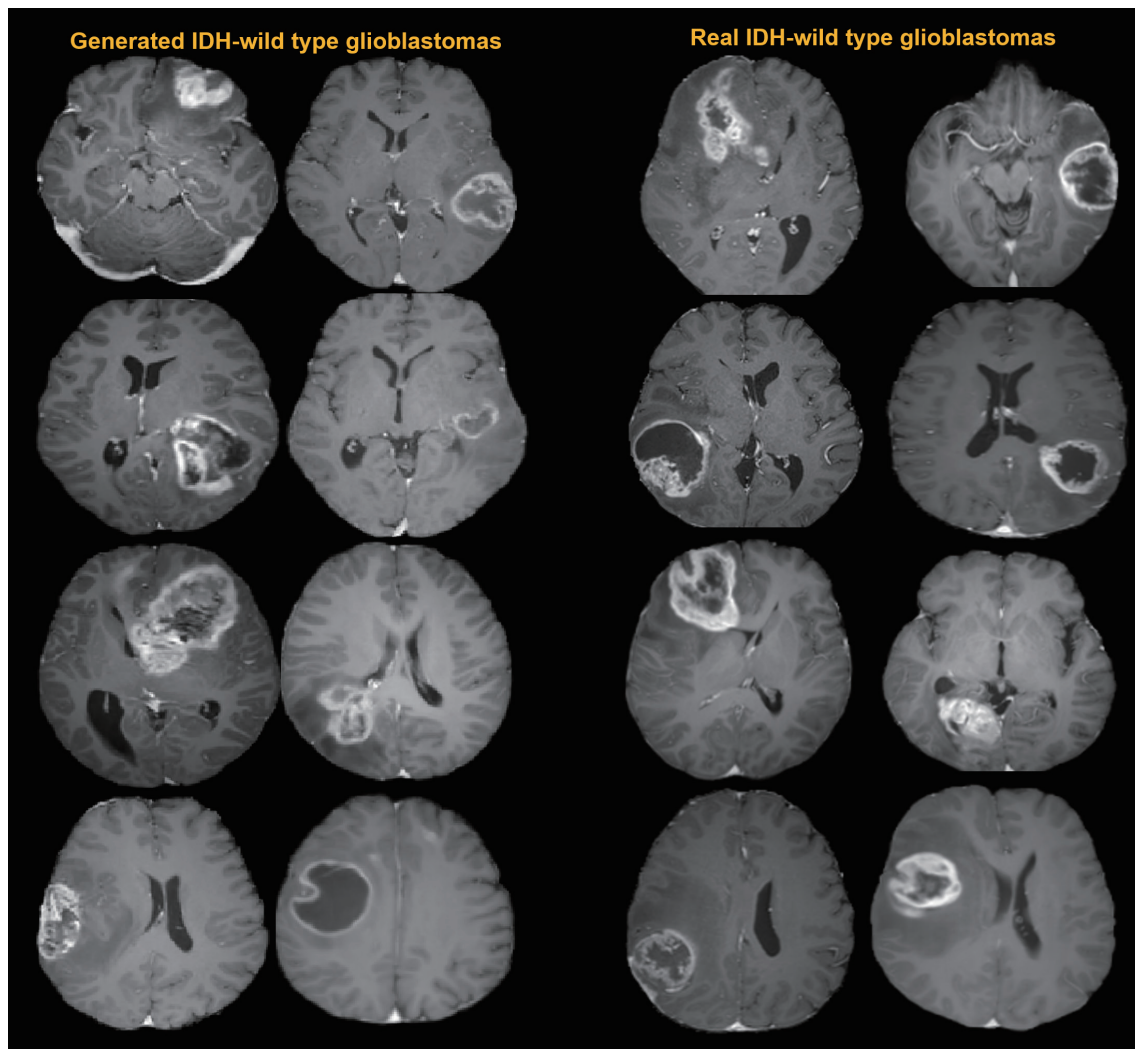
Examples of virtual contrast-enhanced T1-weighted images using generative model for glioblastoma, IDH-wild type (left), as compared with real images of glioblastoma, IDH-wild type (right). IDH = isocitrate dehydrogenase
